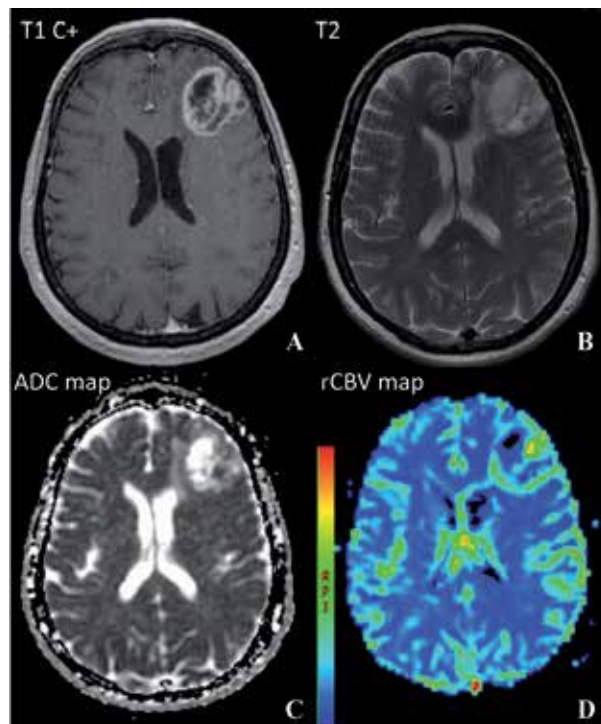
A – T1C MRI; B – T2 MRI; C – Diffusion MRI; D – Perfusion MRI.
